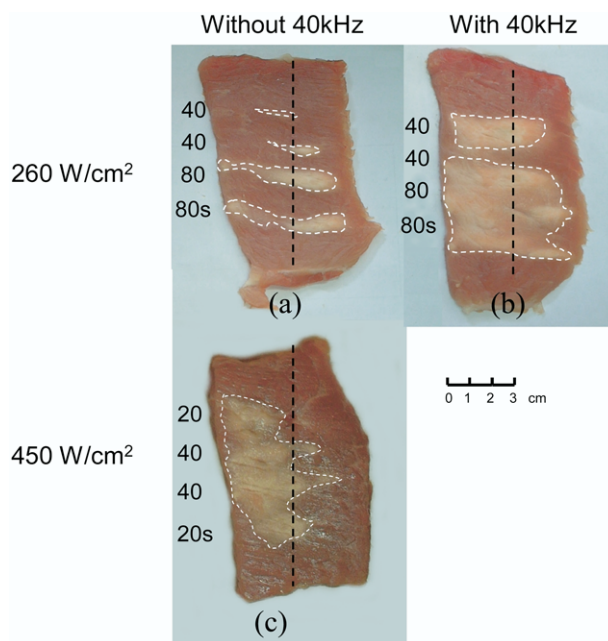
One-dimensional scans for generating large thermal lesions: (a) 566-kHz ultrasound alone (260 W/cm²) for 40 s or 80 s, (b) combined 566 kHz (260 W/cm²) and 40 kHz (1.1 W/cm²) for 40 s or 80 s, and (c) 566 kHz (450 W/cm²) for 20 s or 40 s.
